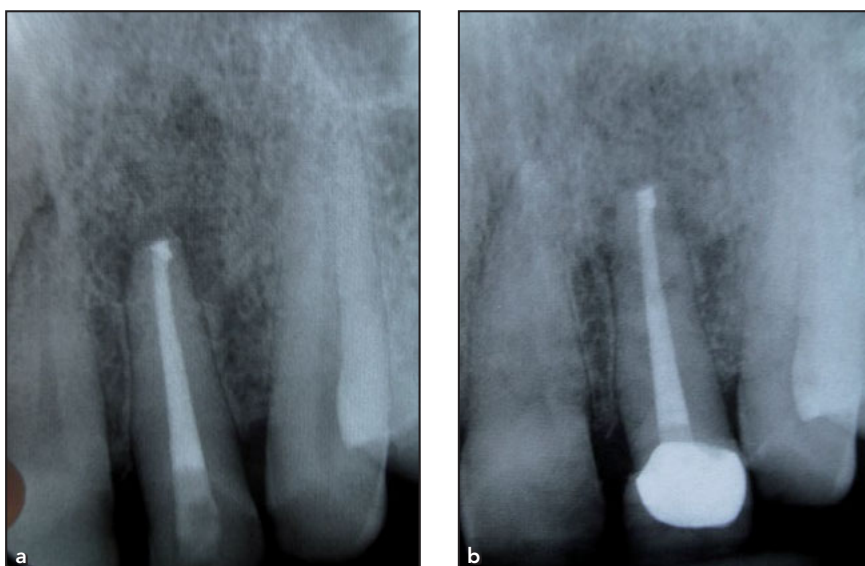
(a) Periapical radiograph taken immediately after the surgery. (b) Resolution of periapical lesion at 6 months postoperative.
